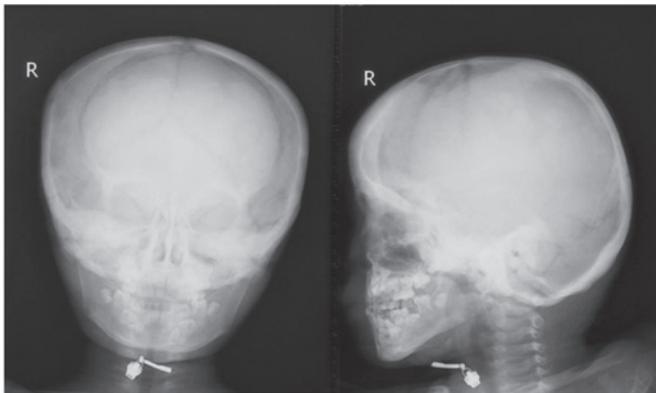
X-ray examination of the 6-year-old patient (P1) revealed the cortical thickening at the base of skull. R, right.
